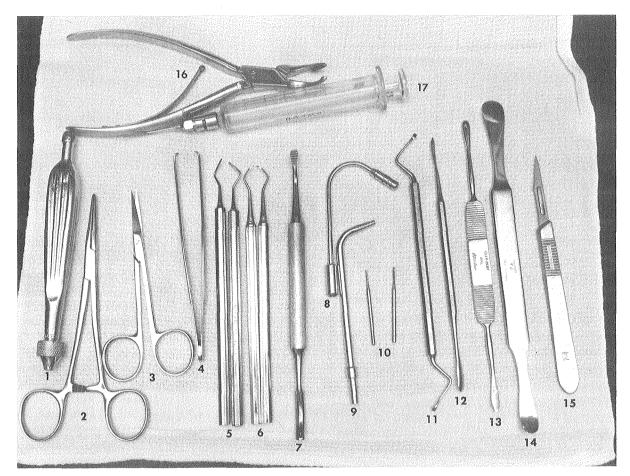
These instruments are all that will be needed in most cases of periapical surgery. Additional instruments for condensing amalgam are necessary for reverse obturation.
